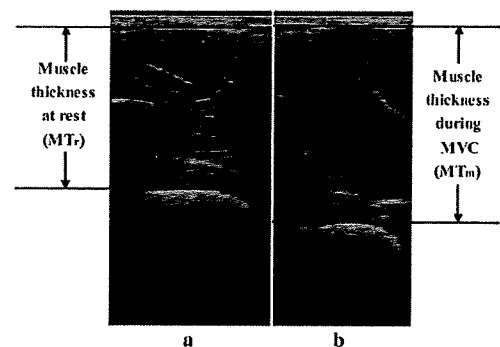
Ultrasonographic images of elbow flexors (a) at rest and (b) during maximal voluntary contraction (MVC).
